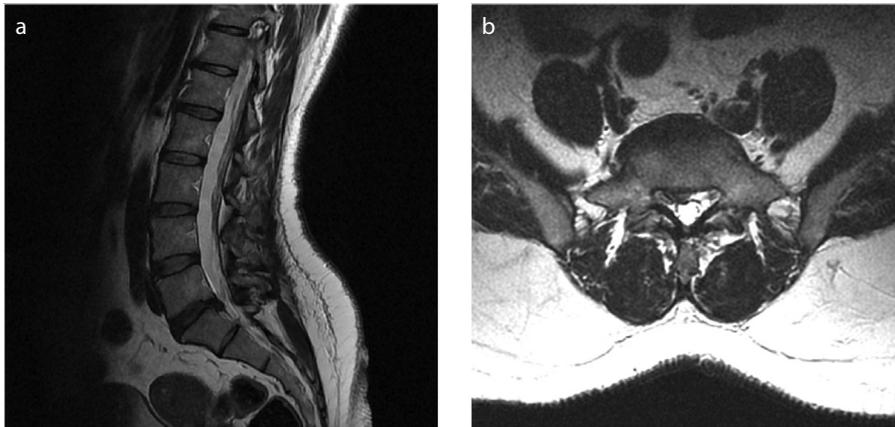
a, b. A 30-year-old female patient with disc hernia without LMM atrophy. Midsagittal T2-weighted image (a) shows sequestered disc hernia at L5-S1 level; dehydration is seen in the disc. Axial T2-weighted image at L5-S1 level (b), shows right lateral compression of the sequestered disc into the dural sac. Multifidus muscle was considered normal (grade 0).
